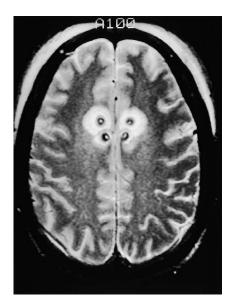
Axial T1-weighted MRI scans obtained 48 hours after repeat anterior cingulotomy. Note the original lesion placed 12 months earlier and the acute lesion anteriorly.
